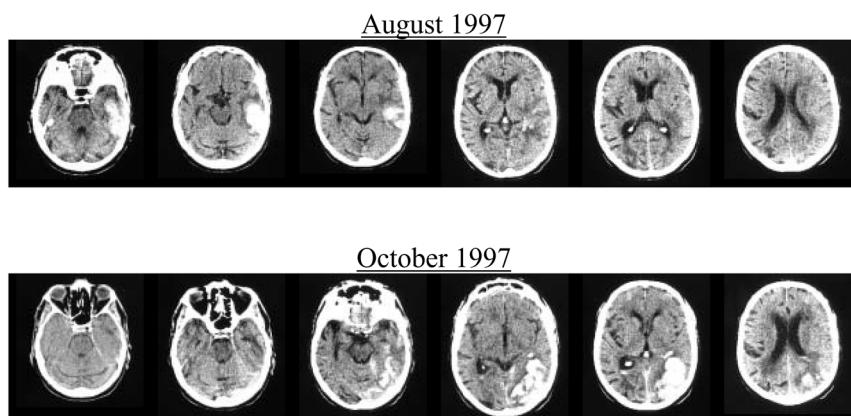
CT scans for patient FD
